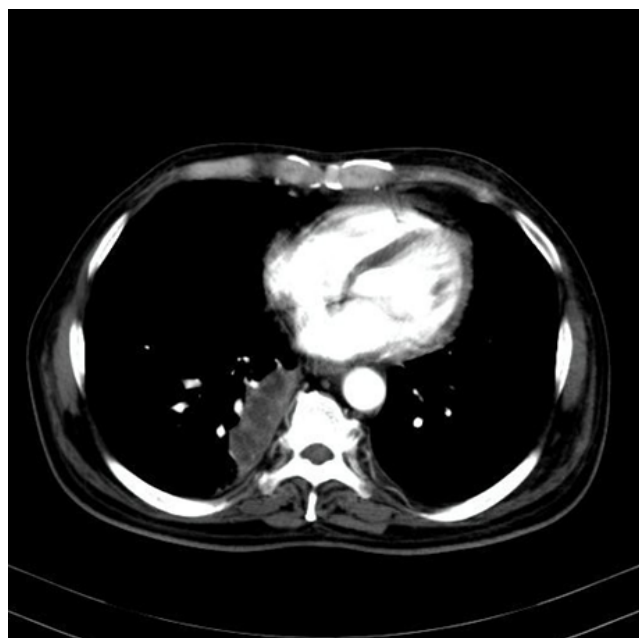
The lung cuts of the Contrast CT abdomen shows a heterogeneously enhancing mass like lesion in the right lower lobe
